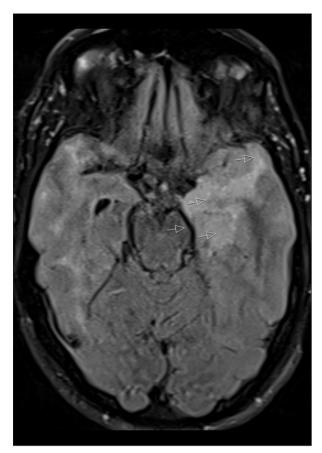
First axial FLAIR-weighted MRI showing hyperintense signal areas diffusely in the white matter and cerebral cortex in the medial and anterior-basal parts of the left temporal lobe (arrows). There is a mass effect with compression of the temporal horn of the lateral ventricle and deformation of the cerebral peduncle to the left (arrow). Similar but less prominent changes are seen in the right temporal lobe.
